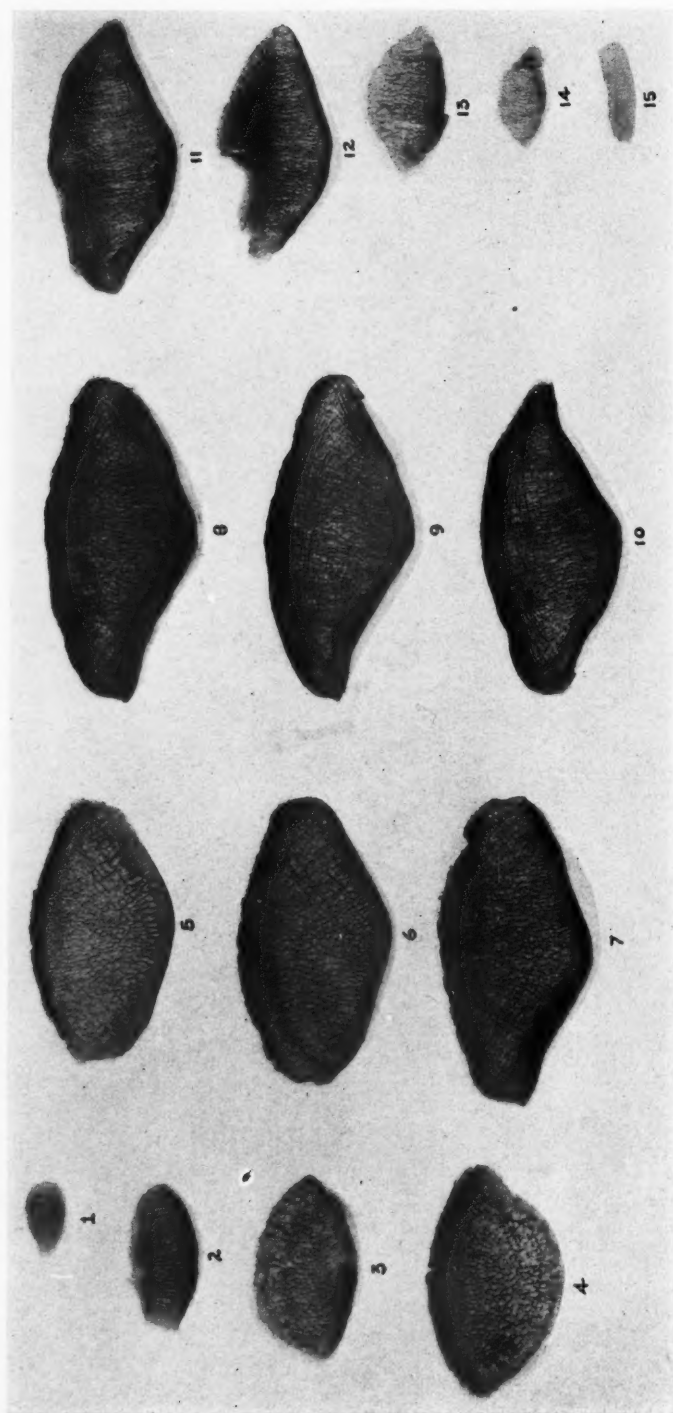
Figs. 1 to 15. Roentgenograms of a single human patella, cut in serial cross-section, each section 1 mm. thick. Figure 1 is the cephalic end of the series and Figure 15 the caudal member of the series. The right angular arrangement of the traction trabeculae and the pressure pillars is clearly evident (natural size).
